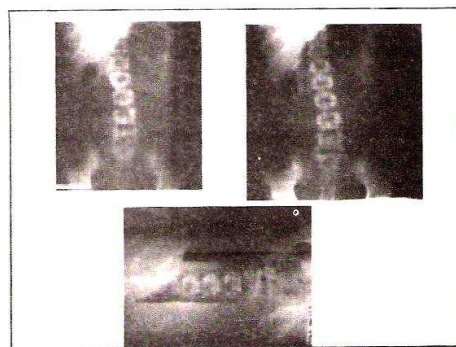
Three positional abdominal radiographic from Cipto Mangunkusumo hospital
